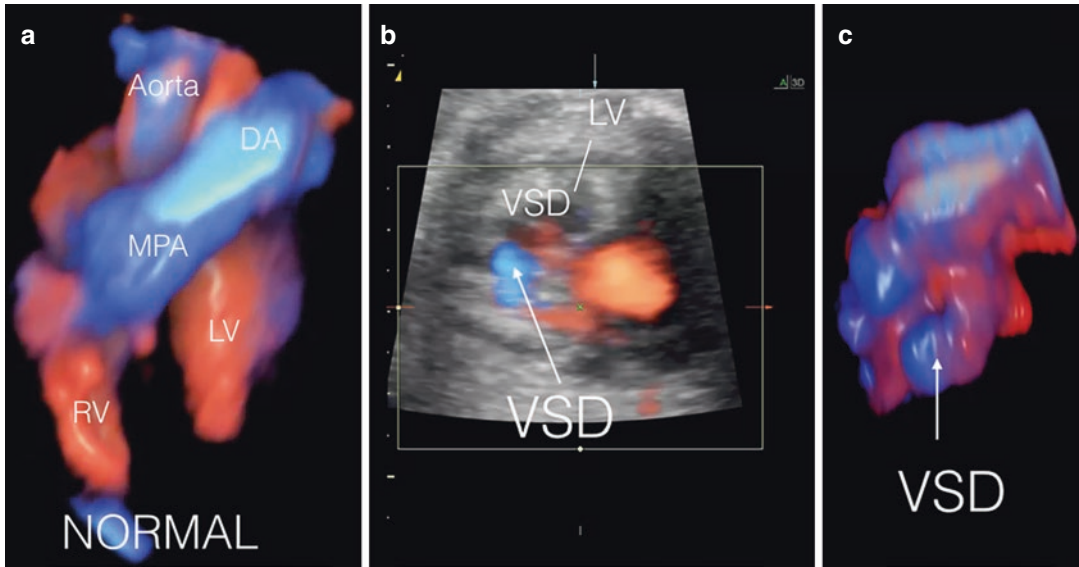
(a) Rendered image of the ventricles and outflow tracts. It is noted the separation between the RV and LV, representing the interventricular septum. (b) A 2D color Doppler image obtained from the STIC volume
